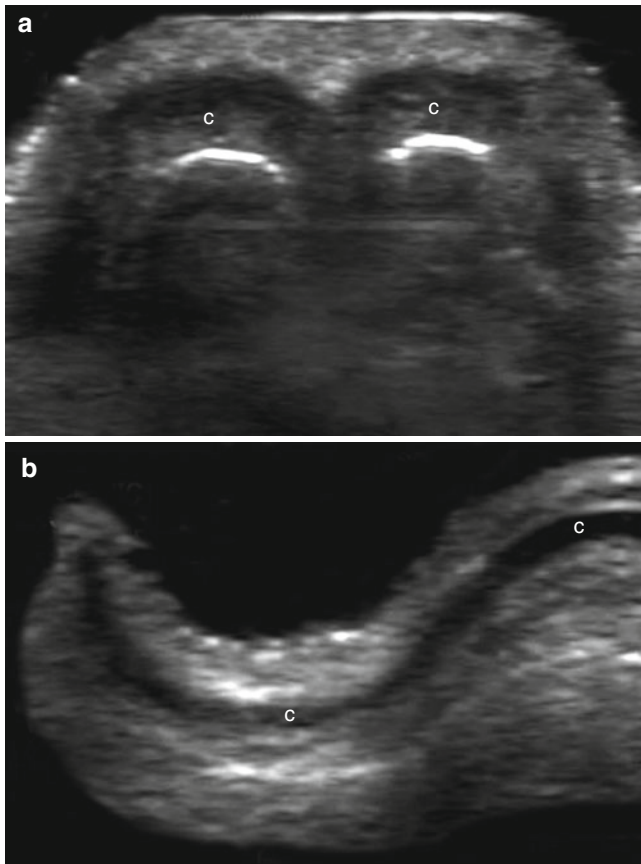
(a, b) Anatomy of cartilage. (a) Ultrasound at the tip of the nose (transverse view). Note hypoechoic nasal cartilages (c). (b) Ultrasound at the middle third of the ear pinna (transverse view). Note hypoechoic sinuous band of the auricular cartilage (c)
